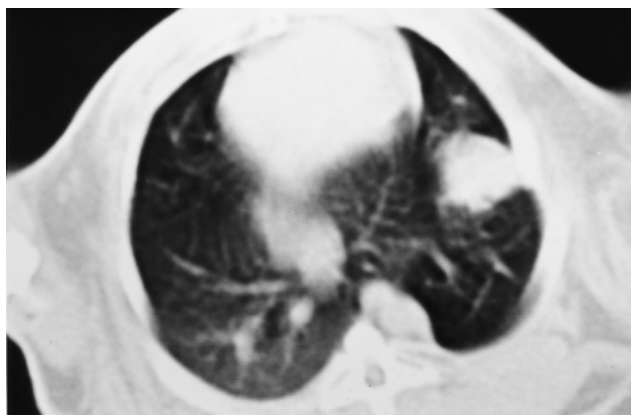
Radiographic findings of the lung just after the injection of ethanol. The injected ethanol was localized unless it spilled out of the lung.
